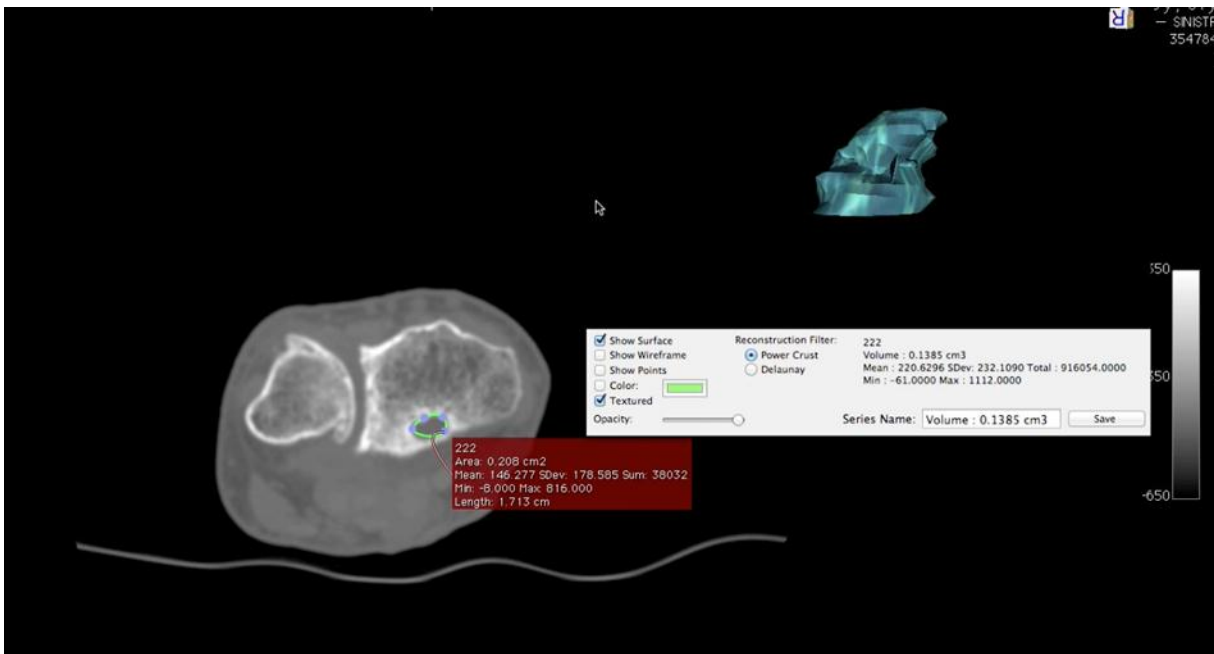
CT images of a wrist. The erosion volume at the distal radio was obtained after the automatic calculation of the area of the erosion by OsiriX software.
